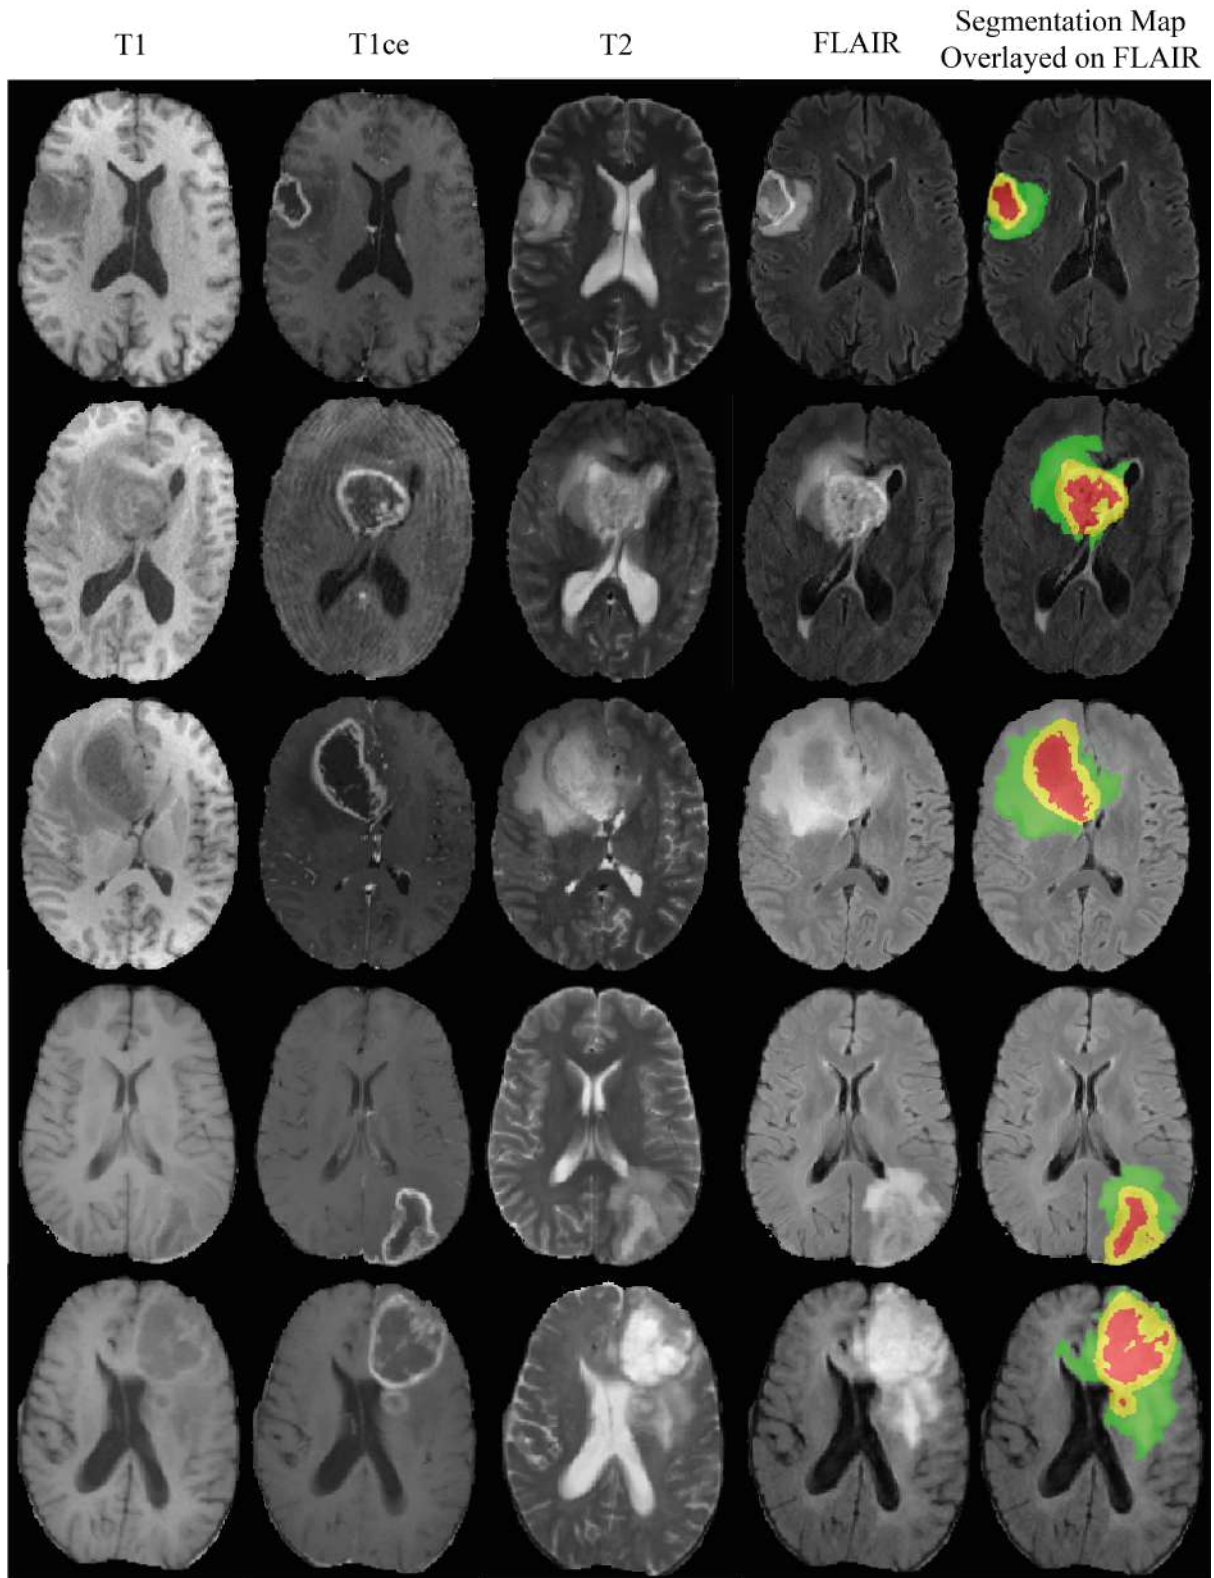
Segmentation Maps Generated Using 2D ResUNet-SEG from the BraTS Validation Dataset for Patient IDs: 2, 8, 15, 22, 34. The Generated Segmentation Maps are Overlayed on the FLAIR Modality of Individual Patients with Labels 1 for NCR and NET (Red colour), 2 for ED (Green colour), 4 for ET (Yellow colour).
